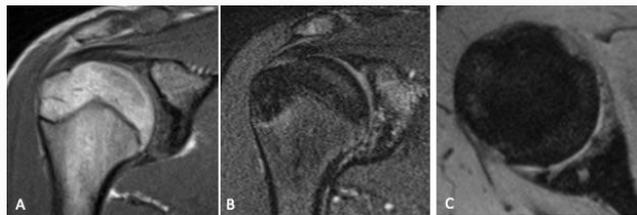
MRI at 2-year follow-up (A) T1 coronal view, (B, C) proton. Sclerotic changes in the subchondral bone and fibrous tissue formation on top of it were noted. Proper conformity with the humeral head was observed.
